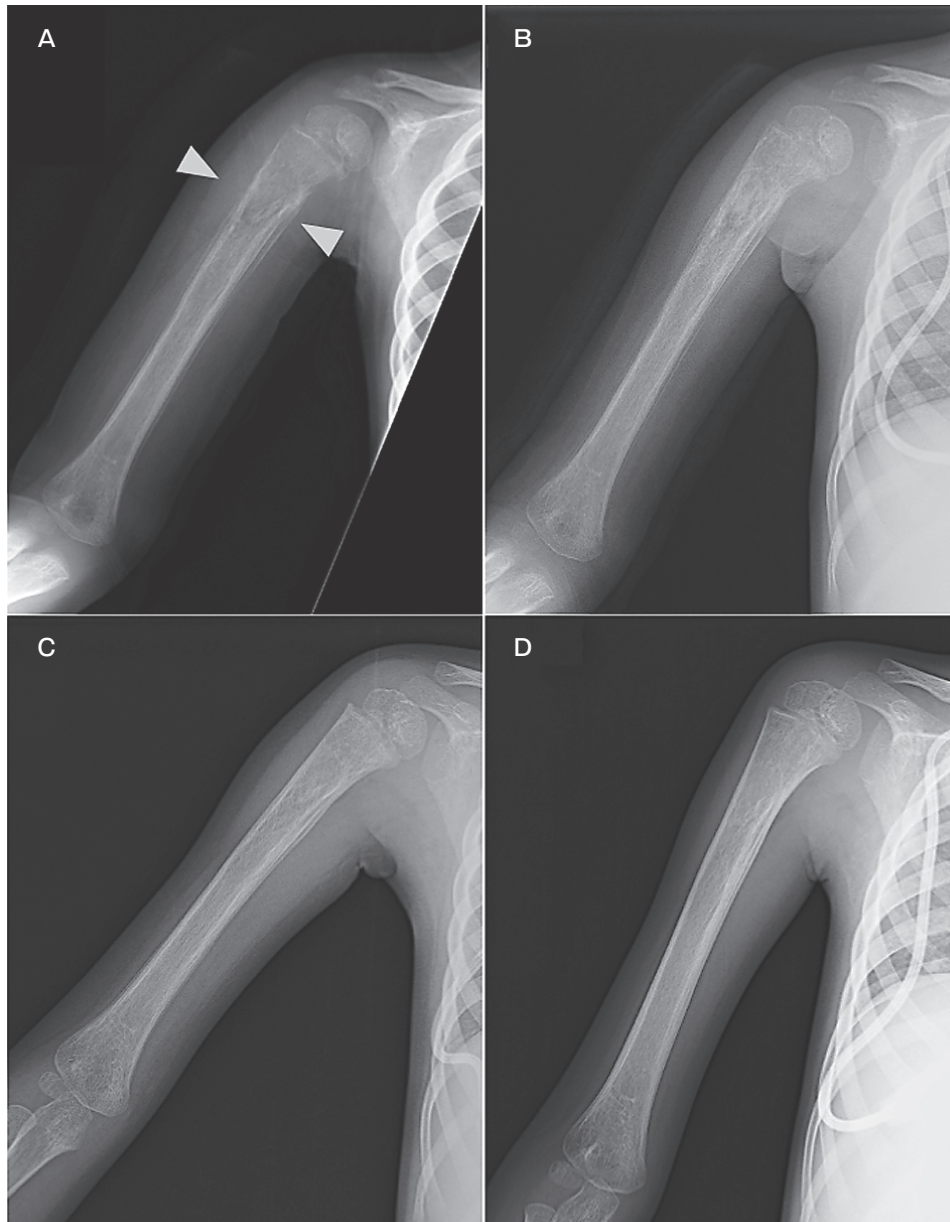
Changes in the osteolytic lesion in the right arm of the patient. X-ray taken (A) before the start of chemotherapy and a tyrosine kinase inhibitor; (B) after an induction course, 1 month after (A); (C) after an early intensification course, 3 months after (A); and (D) after a total of four courses of intensification, 7 months after (A).
